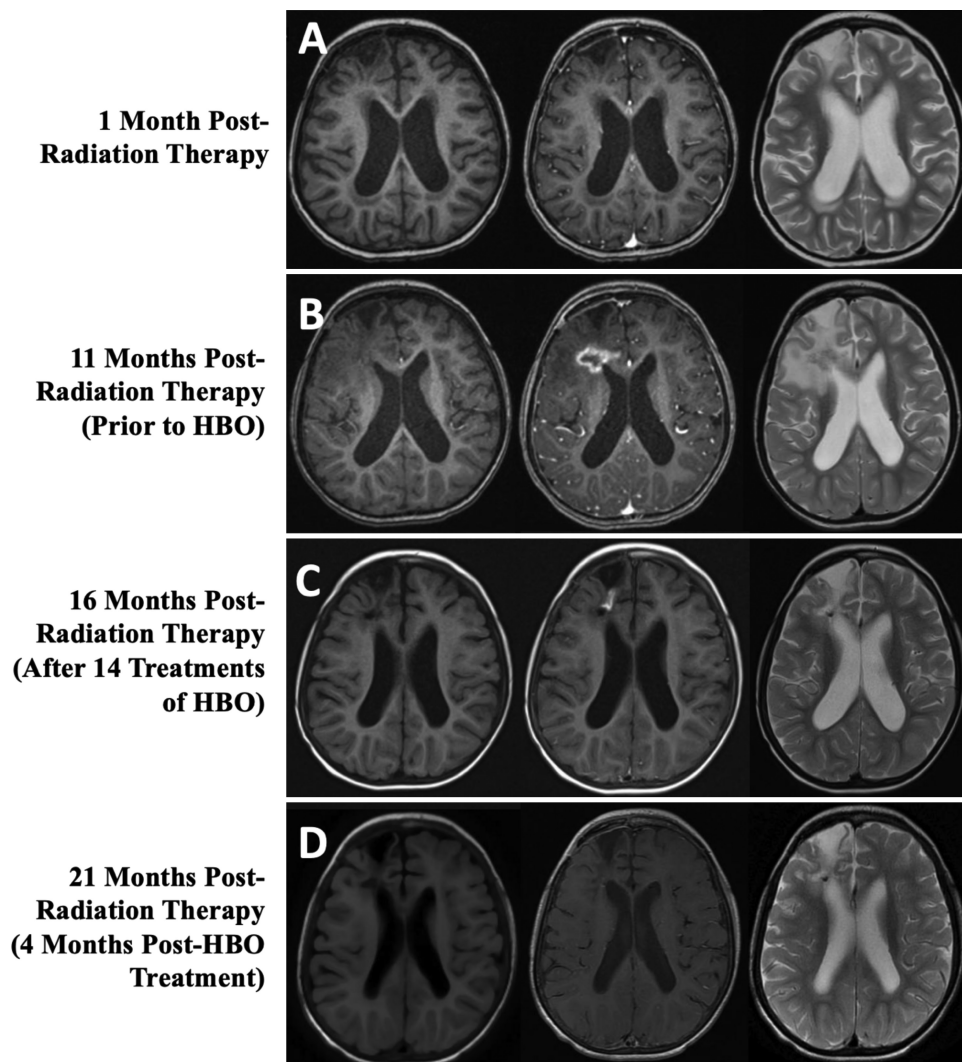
Axial precontrast (*left*) and postcontrast (*center*) T1-weighted and precontrast T2-weighted (*right*) MRI at intervals preceding and following HBOT. A: One month post-RT. B: Eleven months post-RT. C: Sixteen months post-RT and after 14 treatments of hyperbaric oxygen (HBO). D: Twenty-one months post-RT and post-HBO treatment.
